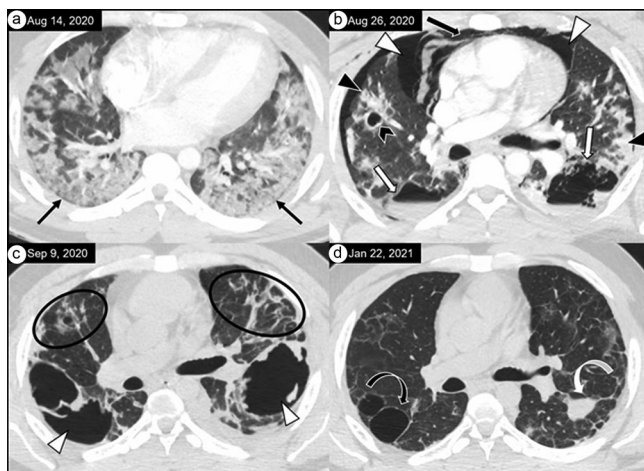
Temporal evolution of chest CT findings in a patient with COVID-19 pneumonia. (a) Typical findings of COVID-19 pneumonia showing diffuse, predominantly peripheral, subpleural ground glass opacities (black arrows) in the bilateral lower lobes. (b) Multifocal consolidation changes (black arrowheads), early pneumatocele (chevron), large cavities with air fluid levels in bilateral lower lobe superior segments (bold white arrows), bilateral pneumothoraces (white arrowheads), and pneumomediastinum (bold black arrow). (c) Further evolution of COVID-19 changes with diffuse interstitial/reticular opacities and architectural distortion (black ovals) and further evolution of bilateral cysts/cavities (white arrowheads). (d) CT of the chest 160 days later showing a significant decrease in the size of the cyst in the right lower lobe superior segment (black curved arrow), complete resolution of the cyst with residual opacity in the left lung lower lobe superior segment (white curved arrow), and further improvement in interstitial opacities.
